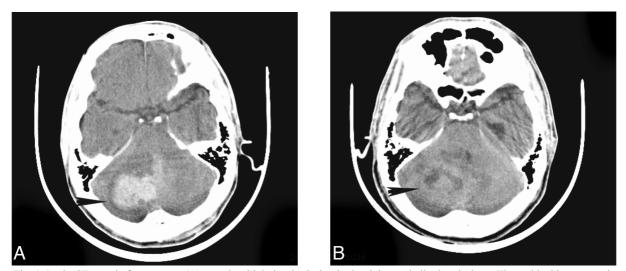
Brain CT scan before surgery (A) reveals a high density lesion in the right cerebellar hemisphere. The residual hematoma in the right cerebellar hemisphere (B) appears iso- to hypodense on brain CT at 6-mo follow-up.
